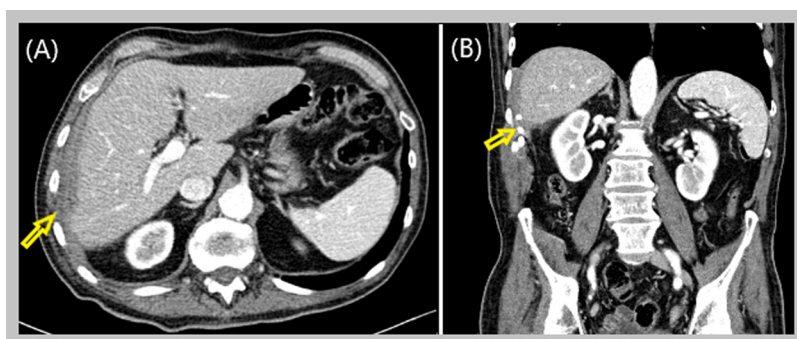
CT abdomen (resolved) resolution of right lateral abdominal wall fluid collection. Right lateral abdominal drain in place without significant fluid collection (yellow arrow [B]) (Color version of figure is available online).
